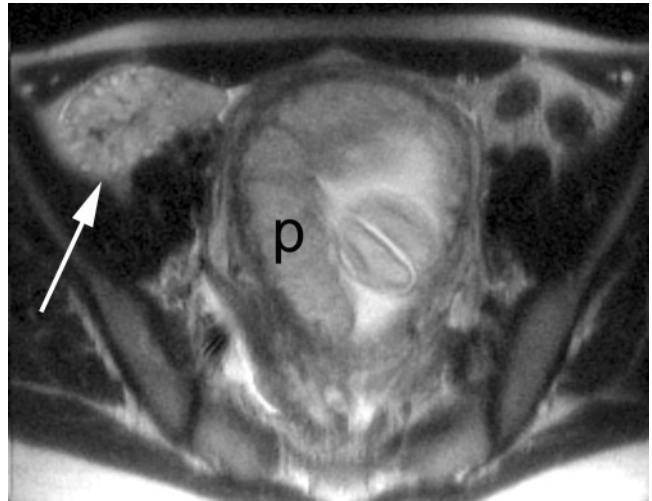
Ovarian torsion in a pregnant patient. Transverse T2-weighted SS-ETSE shows an enlarged, edematous right ovary (arrow) with small peripheral follicles (p, placenta).
